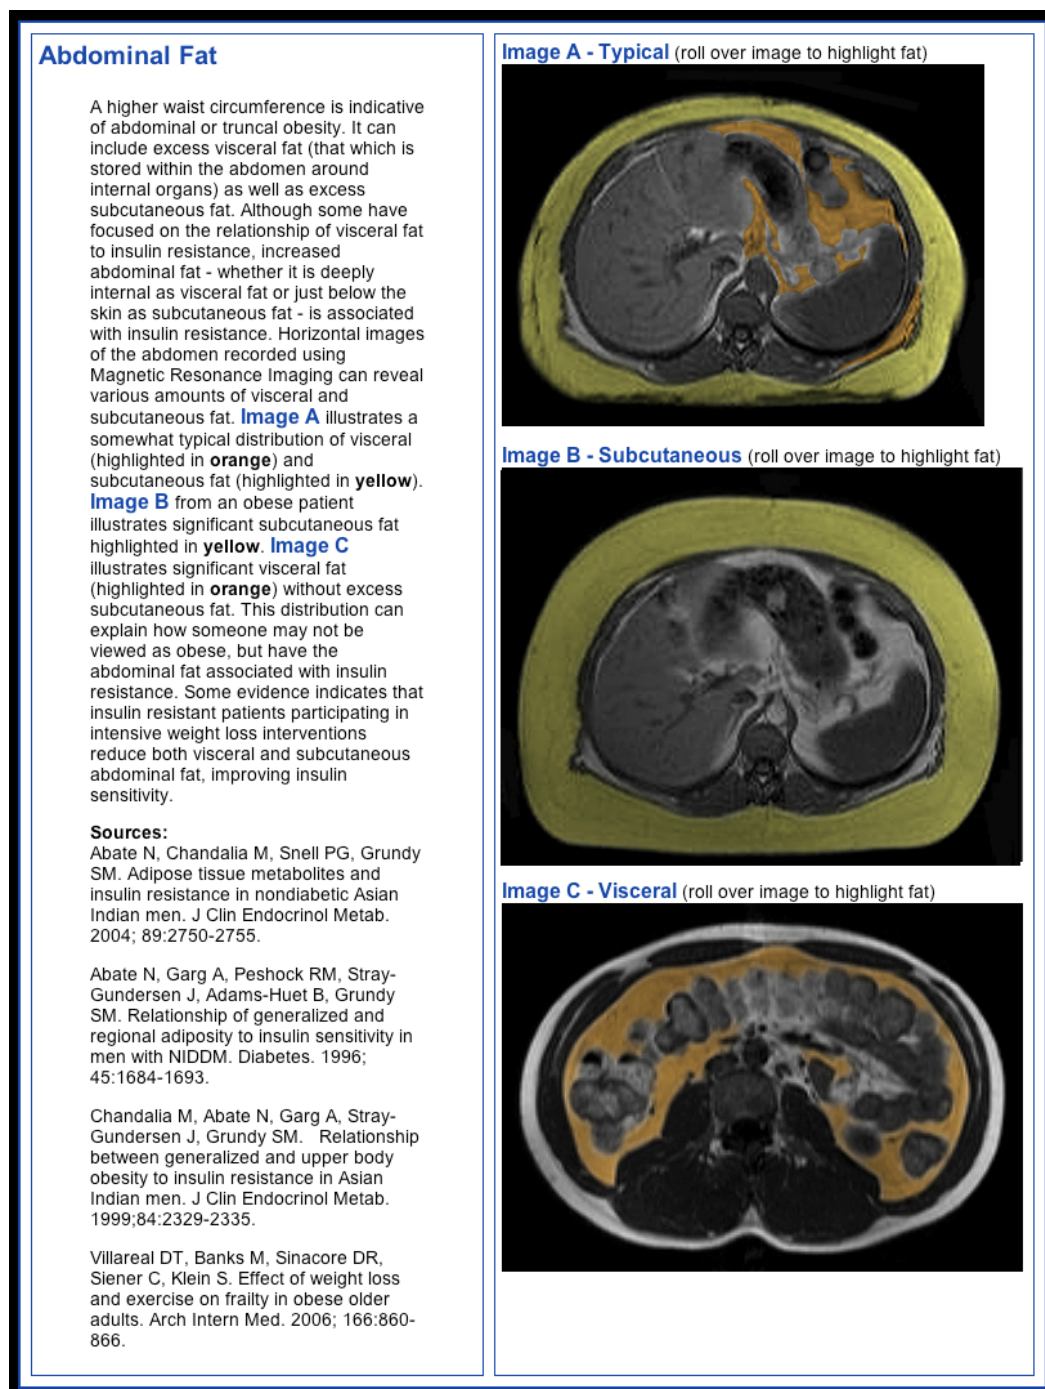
Figure shows three MRI images with the fat distribution, areas highlighted.
